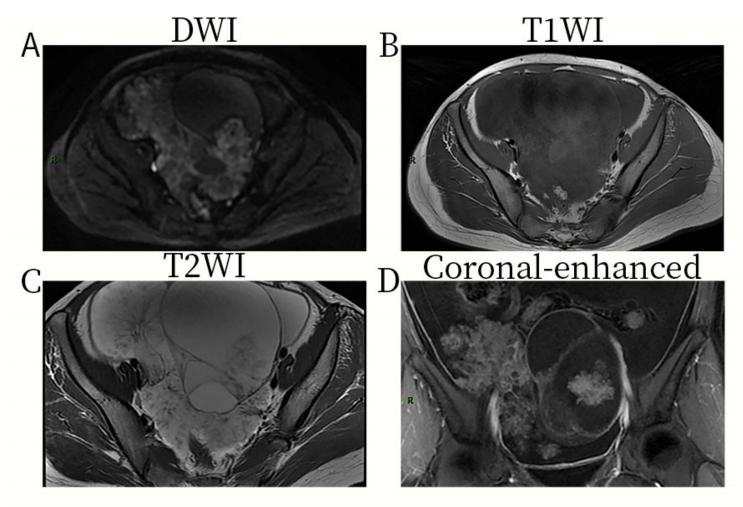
MR images at initial diagnosis. (A) Diffusion-weighted Imaging (DWI) shows a low signal in the cystic component and an enhanced signal in the solid component. (B) T1 Weighted Imaging (T1WI) shows a low signal in cystic and solid components. (C) T2 Weighted Imaging (T2WI) exhibits a high signal in the cystic component. (D) Coronal-enhanced scan of the solid part is obviously enhanced, with an enhanced septal line.
